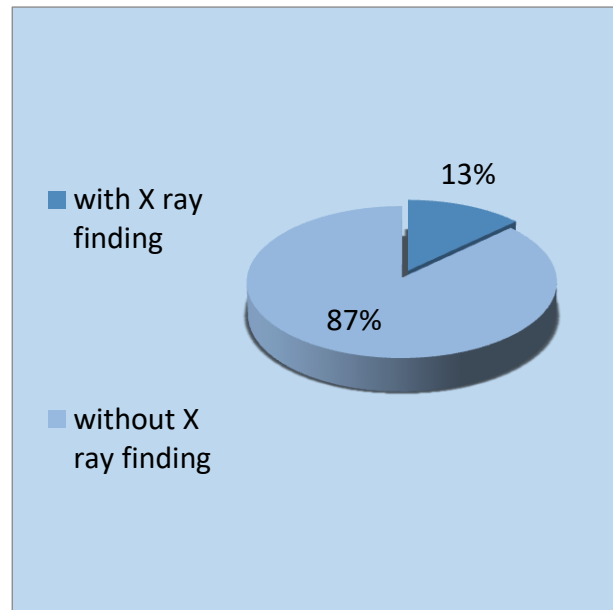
Percentage of PT with X-ray finding to those without.
